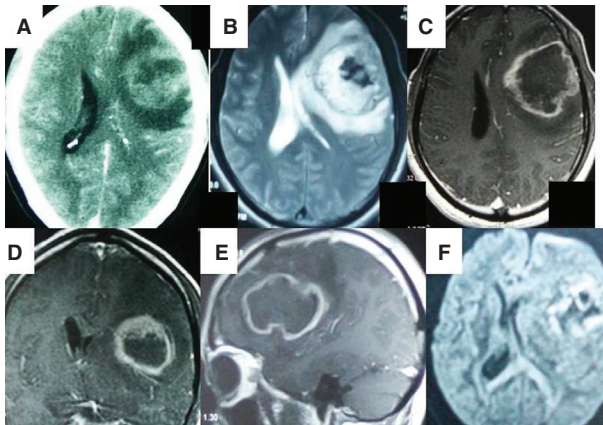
(A). Post-contrast computed tomography of the head shows a left frontal irregularly enhancing intraaxial mass of size approximately 4.5×4.5 cm with perilesional edema. The mass is causing effacement of the adjacent lateral ventricle. The mass is heterogeneously hyperintense on T2-weighted image with central necrosis (B). The peritumoral edema and ventricular compression is well made out on T2 images (B). The mass shows peripheral and ring-like contrast enhancement (C, D, E). The peripheral enhancing part shows hyperintensity on diffusion-weighted films suggestive of diffusion restriction (F). (The image was taken in 3T MRI scanner, GE, USA.)
